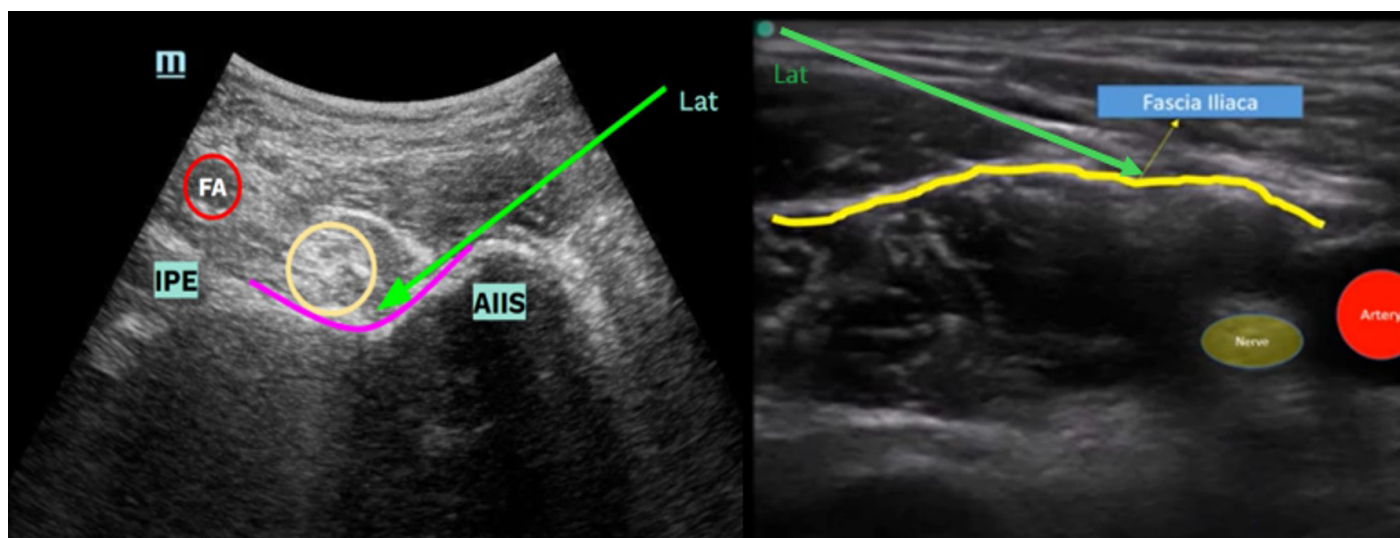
PENG block: The local anesthetic was injected between the iliopubic eminence and the psoas muscle tendon (left); and FICB: The local anesthetic was injected into the iliac fascia compartment (right). Needle insertion was performed from lateral to medial, using an aseptic technique and ultrasound guidance. Embedded text: FA: femoral artery; IPE: iliopubic eminence; AIIS: anterior inferior iliac spine.
